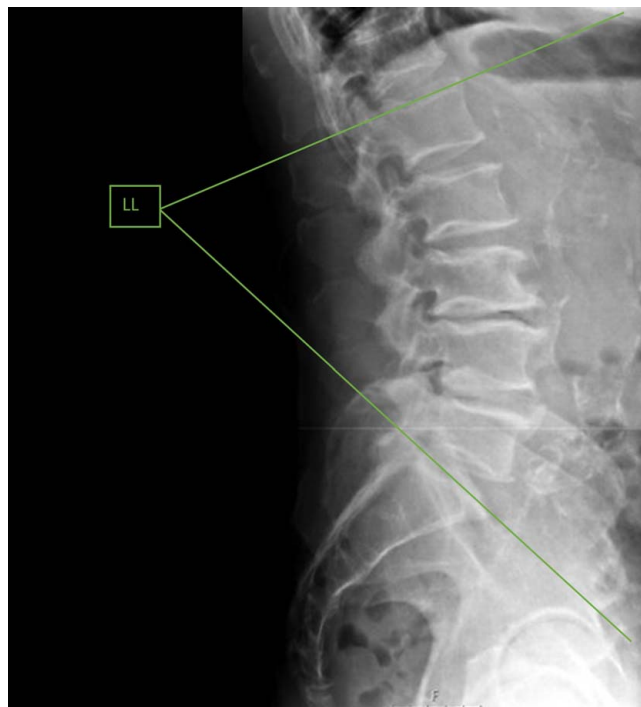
The lumbar lordosis (LL) was measured on lateral x-rays as the angle between the upper endplates of L1 and S1.
